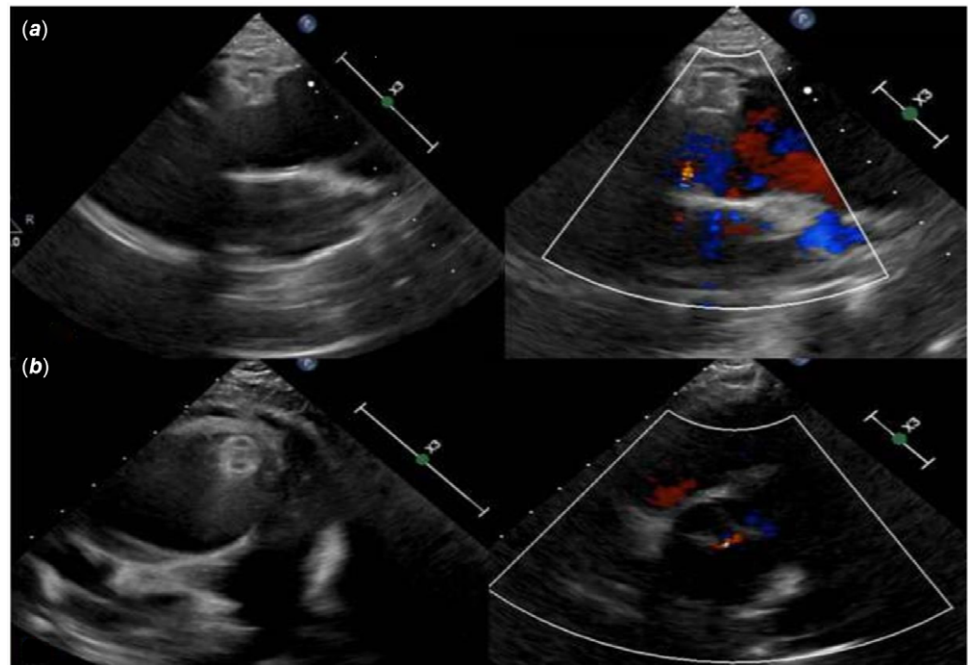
Transthoracic echocardiography (post-device). (a) Parasternal long-axis view shows Amplatzer Vascular Plug II in situ; (b) parasternal short-axis view, trace aortic regurgitation.
